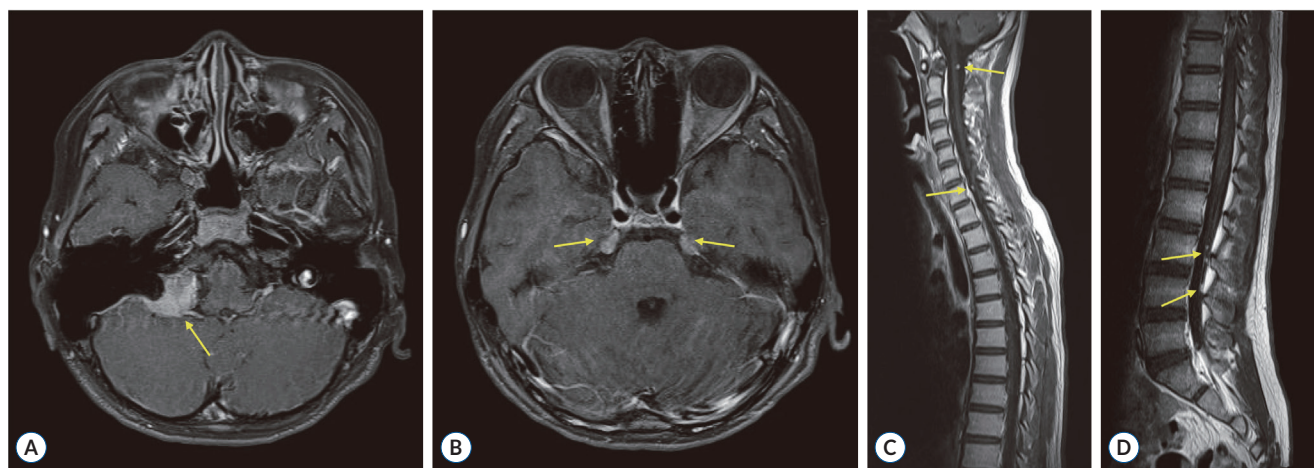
A 12-year-old boy presented to the outpatient clinic with a 2-month history of persistent hoarseness and mild swallowing discomfort, though without significant aspiration. Neurological examination revealed intact extraocular movements, preserved facial sensory and motor functions, and normal visual and auditory function. However, uvular deviation to the left was observed. Brain magnetic resonance imaging (MRI) demonstrated a 3 cm-enhancing mass near the right jugular foramen (arrow) (A), along with smaller enhancing masses in the bilateral Meckel's caves (arrows) (B). Spine MRI revealed multiple small enhancing nodules along the cervical and thoracic spinal cord and the cauda equina (arrows) (C and D). There was no sign of vestibular schwannomas. These findings raised suspicion of a tumor-prone genetic syndrome, such as neurofibromatosis (NF) type 2. The patient had no family history of similar disorders or intracranial schwannomas. Germline genetic testing for the *NF2* gene revealed no pathogenic alterations. A diagnosis of probable SWN was made. The patient was managed with regular imaging follow-ups due to the stability of his symptoms. At a 4-year follow-up, the patient's hoarseness and mild swallowing discomfort remained stable, and all tumors showed no significant growth on imaging.
